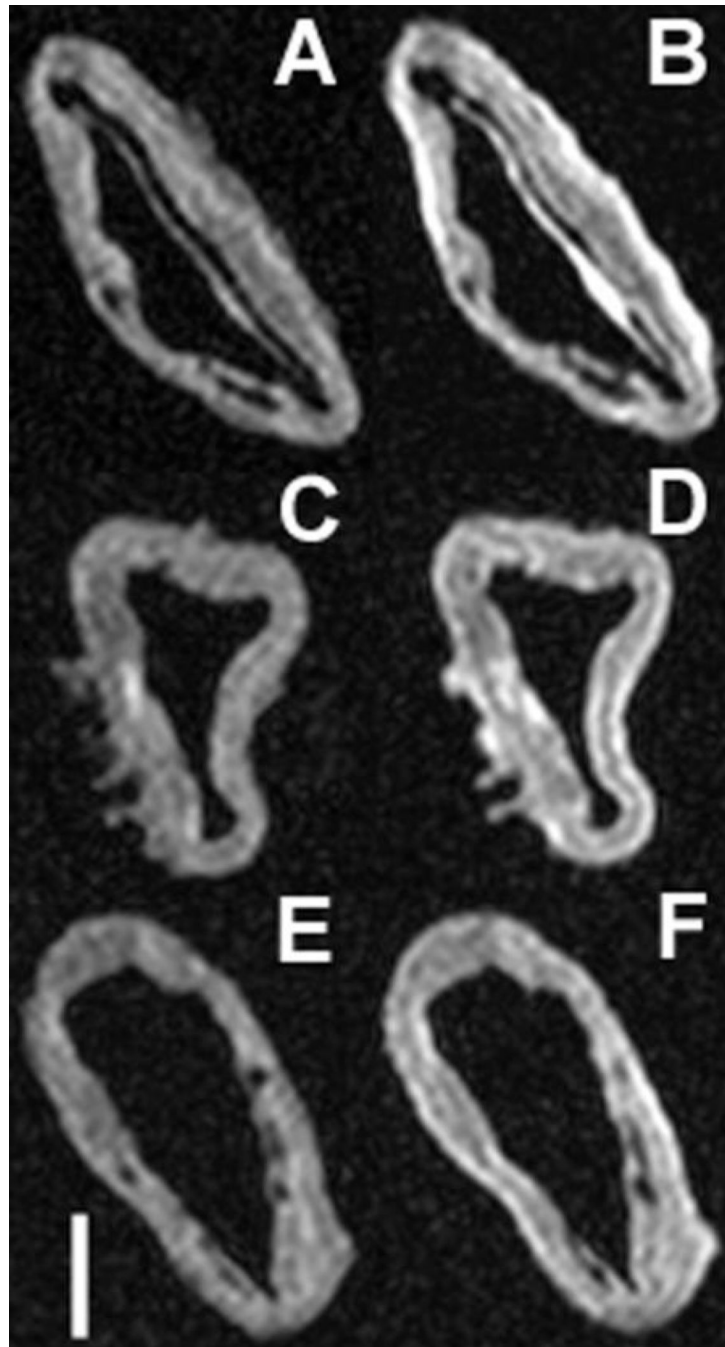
Pre- and post-contrast MRI of aorta incubated with NPs
